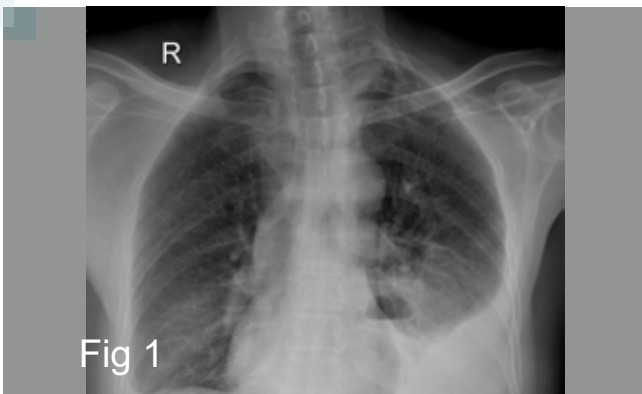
Chest x-ray showing bilateral pleural effusion with pneumomediastinum
